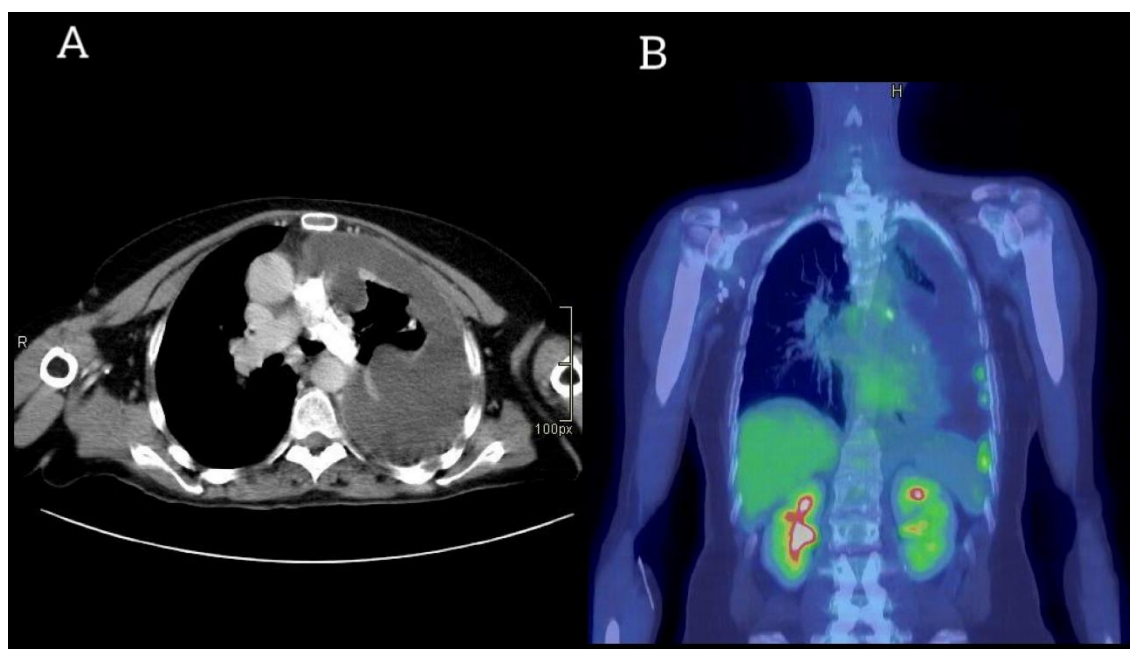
A: Chest CT without intravenous contrast is requested in which the occupation of the light of the left main pulmonary artery persists. B: shows an increase in metabolism in the pleura in relation to pleural implants.
